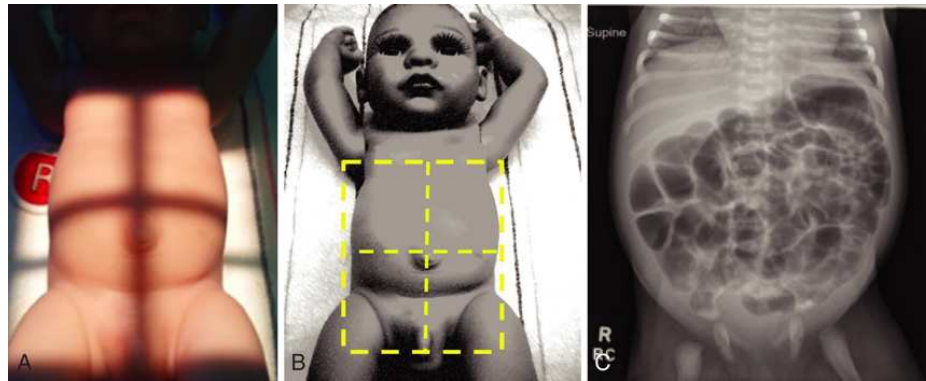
(A) AP abdomen, central ray directed at level of iliac crest. (B) AP abdomen, radiation light field. (C) AP abdomen radiograph.
